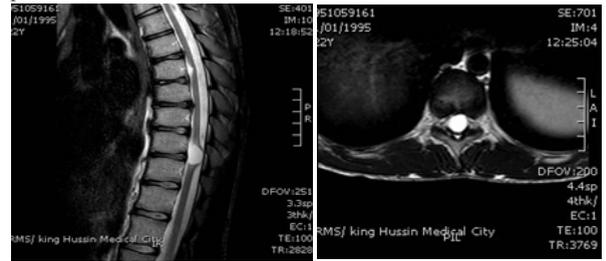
Sagittal and axial MRI showing small intramedullary cystic lesion.
